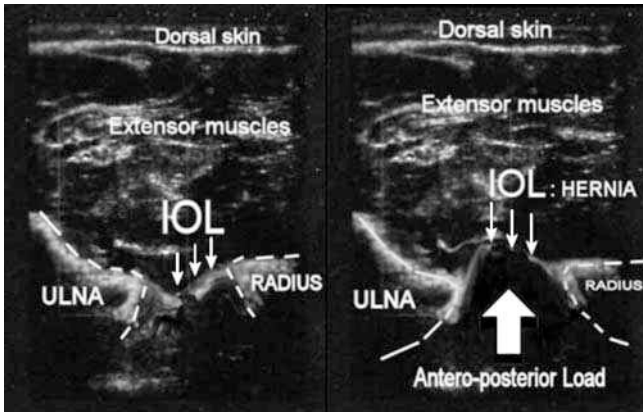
Ultrasonographic (US) axial slices of the forearm. On the left, the interosseous membrane was disrupted. On the right, the “hernia muscular sign” could be observed: an anteroposterior load was applied and the anterior muscles passed through the membrane’s tear
